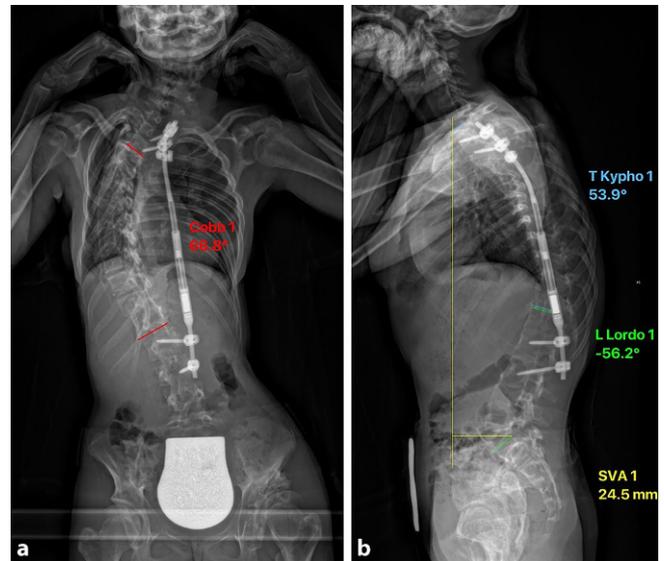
▲ Postoperative anteroposterior (a) and lateral (b) radiographs 3 weeks after rod distraction. *T Kypho* thoracic kyphosis, *L Lordo* lumbar lordosis, *SVA* sagittal vertical axis
